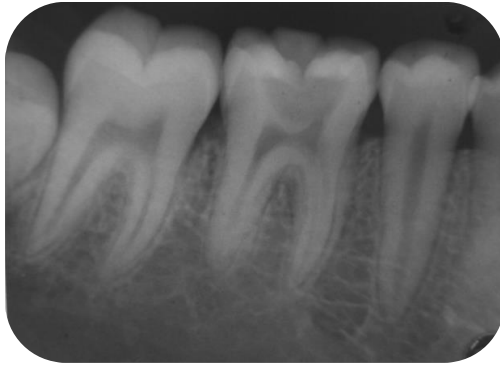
Pre-operative radiograph where radix is not visible
